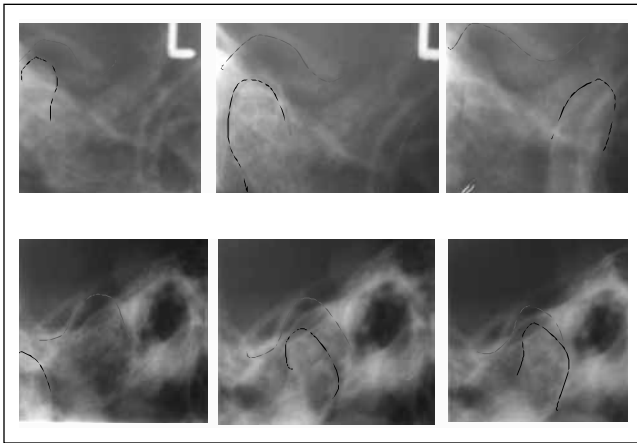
Transcranial radiograph, showing the condyles in a distalized position.
